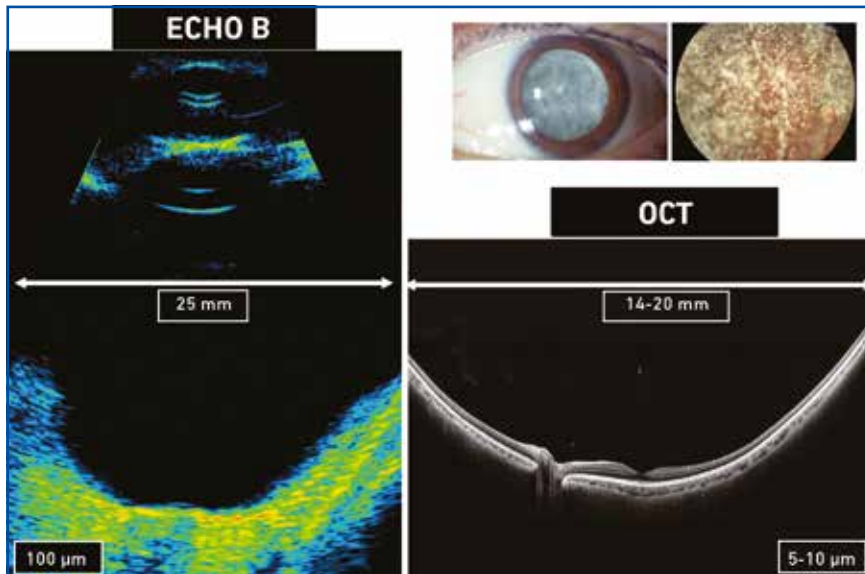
Comparison of an ultrasound section and an OCT section. Note the lower resolution but wider examination window for the ultrasound, possible even in the event of disturbances of the transparent media.
